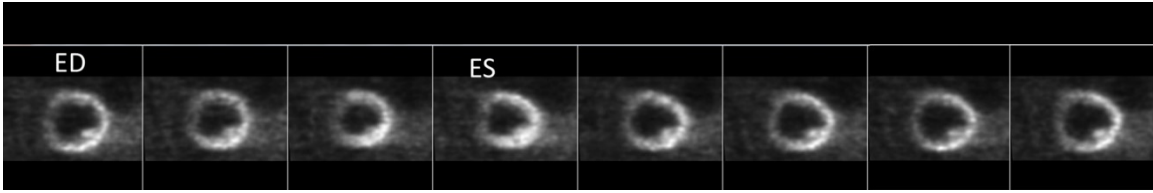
8-frame cardiac gated images of an ^{18}F FDG study in short-axis view
